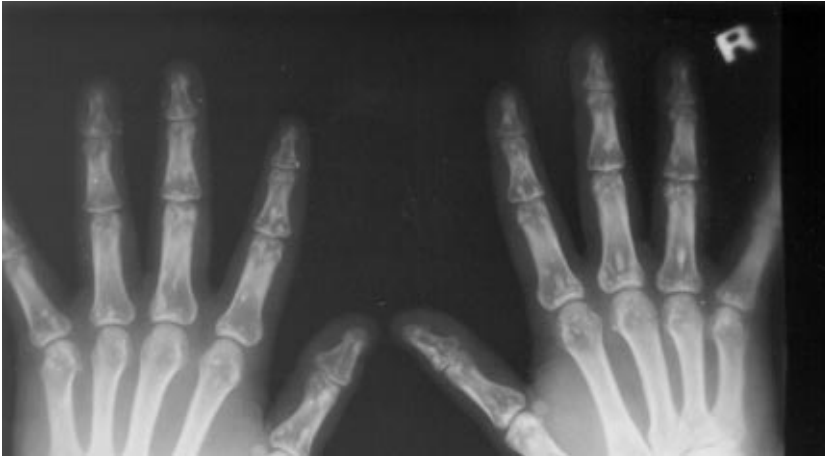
Osteopoikilotic lesions on hand roentgenogram of the patient.
